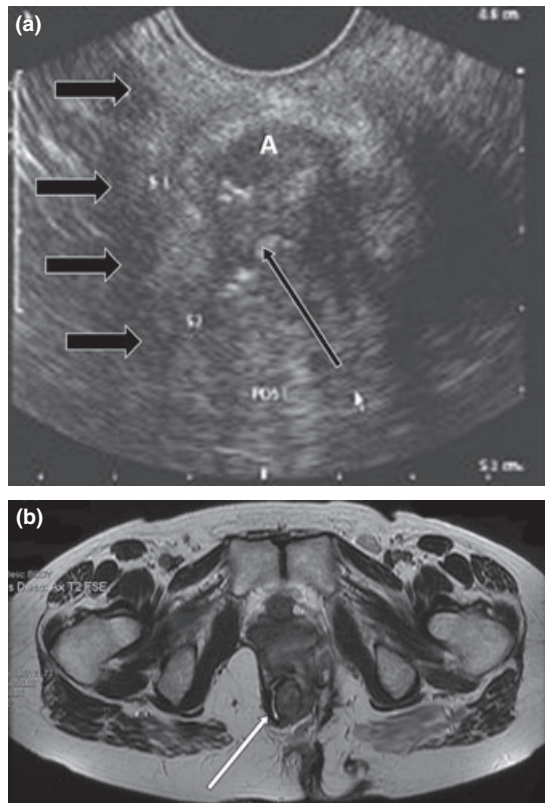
(a) Transperineal axial ultrasound in a female with severe anal stenosis preventing insertion of an endoanal probe. A circuitous fistula beginning in the midline posteriorly (arrow) extends anteriorly (arrowheads) and was traced to the right labium majorum, although a recto-vaginal fistula could not clearly be demonstrated on sagittal transperineal ultrasonography views. A, anal canal. (b) The corresponding MRI image (T2 FSE image) showing a circuitous gadolinium-enhancing track extending alongside the anal canal to the perineum (arrow).
